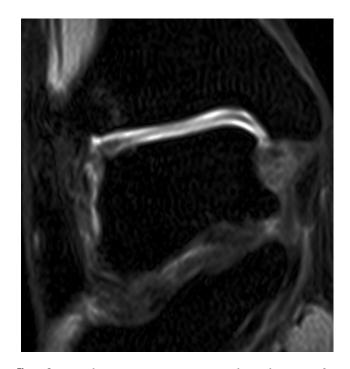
Coronal magnetic resonance image obtained 2 years after AMIC showing recovery of the subchondral bone and excellent defect fill.
